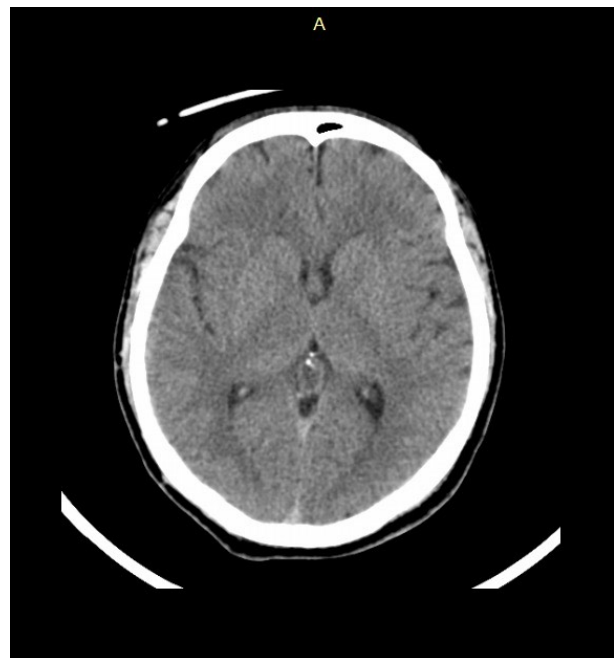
Cranial CT Scan showing no acute intracranial infarct or hemorrhage
